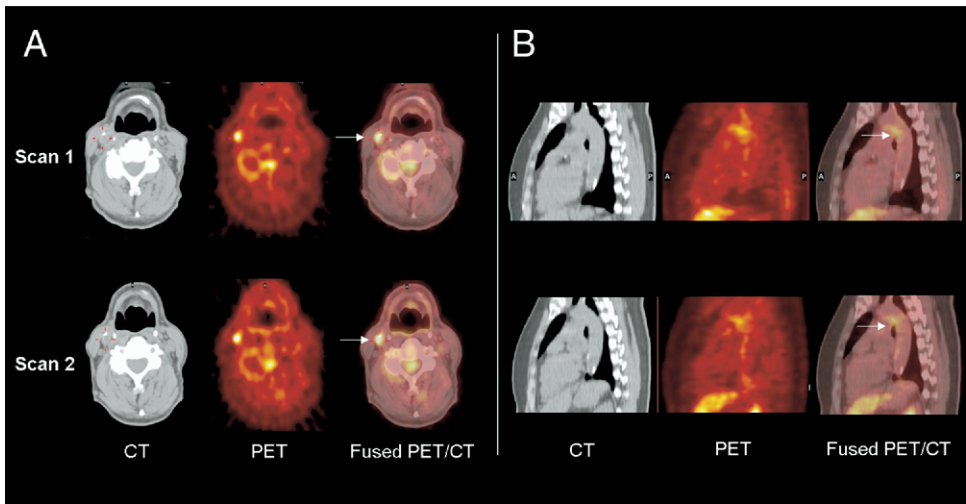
Carotid and Aortic PET/CT Images Over 2 Weeks
